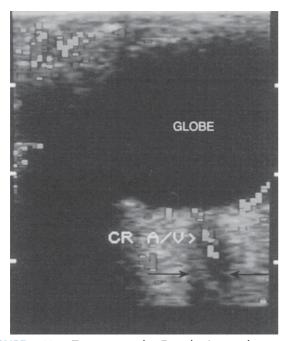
Transverse color Doppler image demonstrating the normal central retinal (CR) artery and vein located within the hypoechoic optic nerves (*arrows*). Blood flow is also visualized at the back of the eye corresponding to flow in retinal and choroidal vessels. Red and blue indicate flow toward and away from the transducer, respectively.
